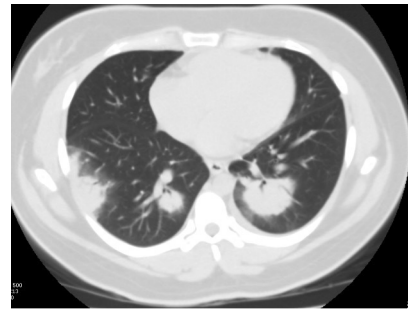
CT chest without contrast demonstrating multiple bilateral lung nodules measuring up to 4.0 cm and a 1.2 cm consolidation noted at the lingula with a few areas of ground glass opacities.
